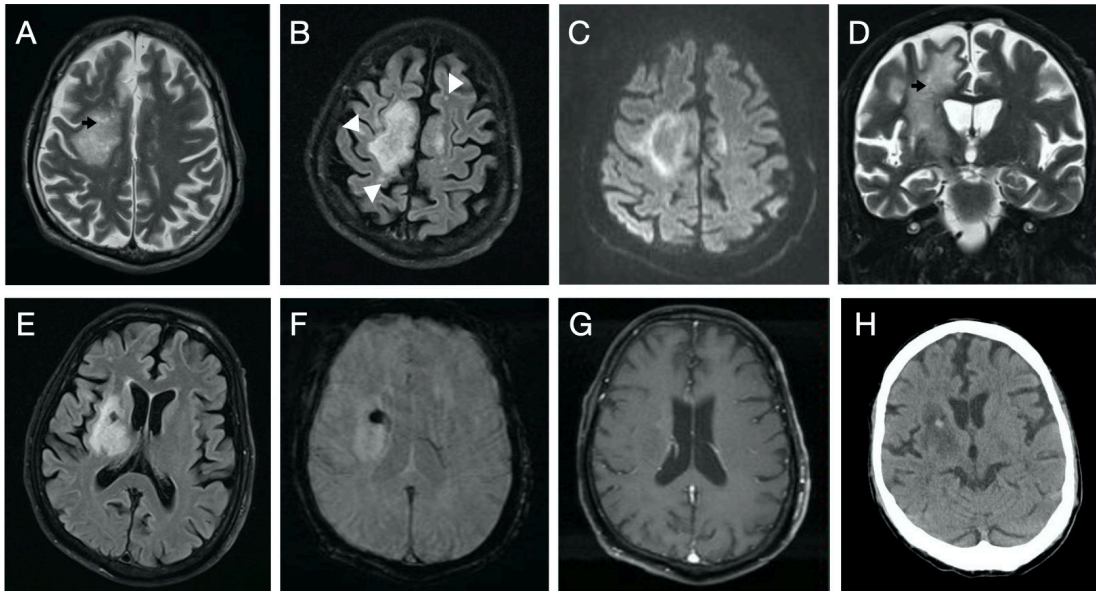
(A) Axial T2 showing white matter hyperintense lesion with vacuoles within (black arrows); (B) Axial T2 FLAIR showing small hyperintense lesions around the main lesion (milky way sign); (C) peripheral diffusion hyperintense along the spreading edge (rim and core pattern); (D) Coronal T2 section showing the extent of lesion; (E) Axial T2 section showing focal hypointensity within the main lesion; (F) SWI sequence showing blooming within in the lesion; (G) no contrast enhancement (H) CT Brain confirming bleed within the main lesion.
